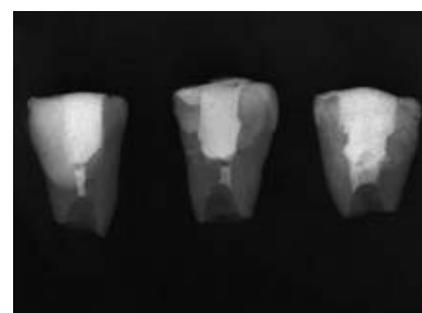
X-ray images following apicoectomy and root-end cavity preparation (From left, 3-, 5- and 7-W laser application). The bottom surface of the cavity of all samples was round and U-shaped, there was no deviation in the direction of formation, and the dentin was sufficiently thick.
